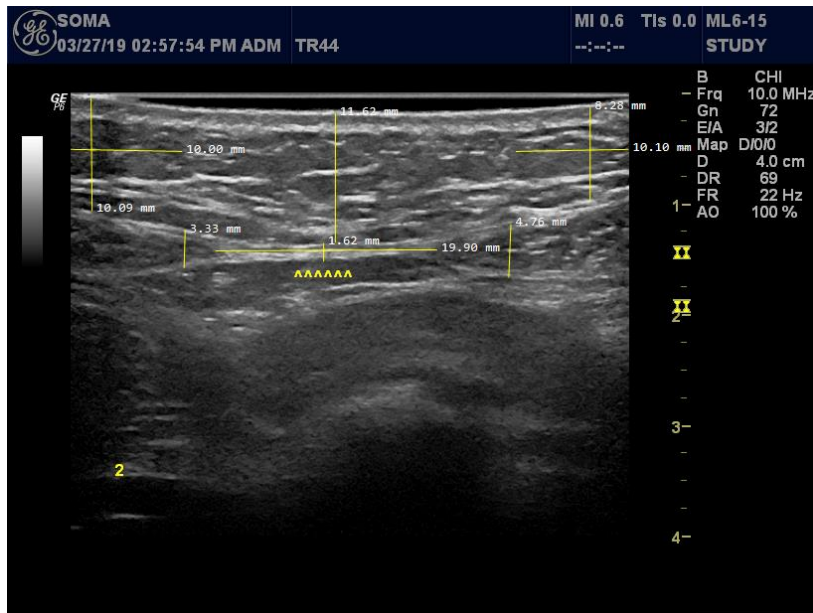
Ultrasound Image with IRD Measured Offline
